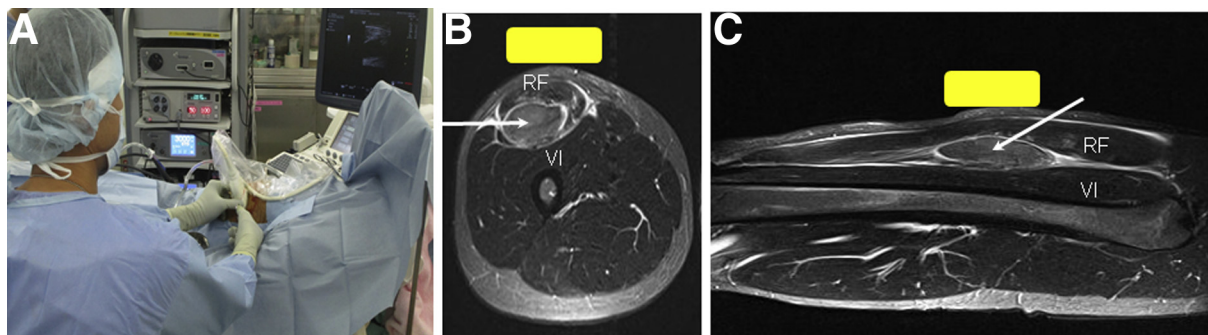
Operative setting of ultrasonography-guided muscle hematoma evacuation. (A) Surgeon, ultrasound (US) probe, affected limb (left thigh), and US monitor were in line with each other. (B) The US probe (yellow square) was placed on the axial plane of the hematoma and rectus femoris (RF) and vastus intermedius (VI). This in-plane approach to the hematoma is easier because the needle (white arrow) can be visualized parallel with the US probe. (C) If the US probe (yellow square) is put on the sagittal plane of hematoma, RF and VI, visualization of the needle is more difficult because the needle is not parallel to the US probe.
